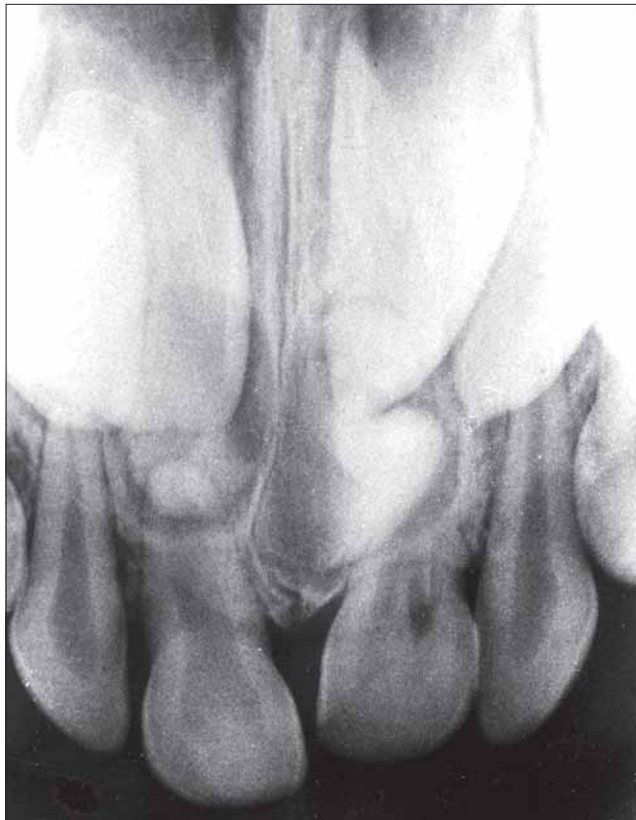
Case 1. Periapical radiograph showing two lesions of compound odontoma.
